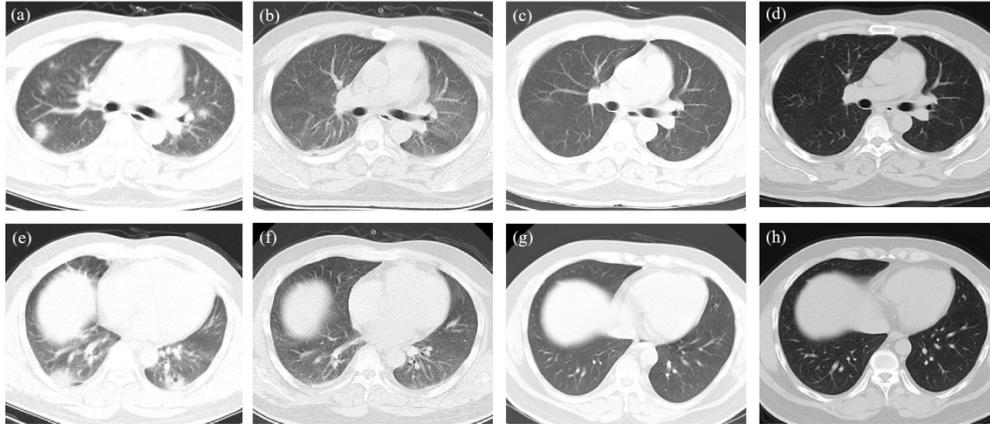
The chest CT scans from a 35-year-old male COVID-19 patient. (a, e) the chest CTs at admission. Chest CT presented multiple consolidation in the upper and lower lobes, GGO in the peripheral lung, and small cavity in the lower lobe of left lung. (b, f) the last chest CT before discharge. The consolidations were absorbed mostly and transformed into small patchy GGO. (c, g) the chest CT two weeks after the discharge. The GGO was absorbed completely. (d, h) the chest CT four weeks after the discharge showed no recurrence.
